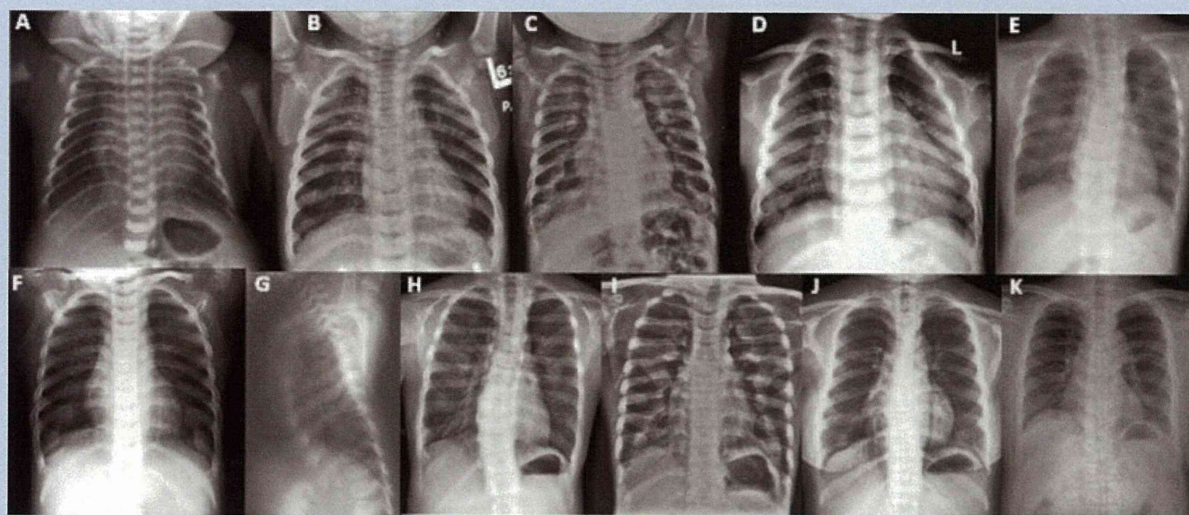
Radiographs of the chest. A: Patient 1 at age 2 days, (B) Patient 2 at age $1^{4/12}$ years, (C) Patient 5 at age 2 years, (D) Patient 3 at age 4 years, (E) Patient 4 at age 5 years, (F) and (G) Patient 6 at age 8 years. Note a narrow thorax in (A), (C–E), and short ribs with cupped, flared anterior ends in all. Thoracic narrowing is modest in (B) and (F). Mild irregularities of the proximal humeral metaphyses are seen in (A,B) and (C). H: Patient 4 at age 10 years, (I) Patient 5 at age 12 years. Cupping and flaring of the anterior ends of the ribs are most conspicuous in late childhood. Thoracic narrowing is modest. J: Patient 6 at age 15 years, (K) Patient 7 at 23 age years. A narrow thorax is persistent, but cupping and flaring of the anterior ends of the ribs are less conspicuous than those at younger ages.
